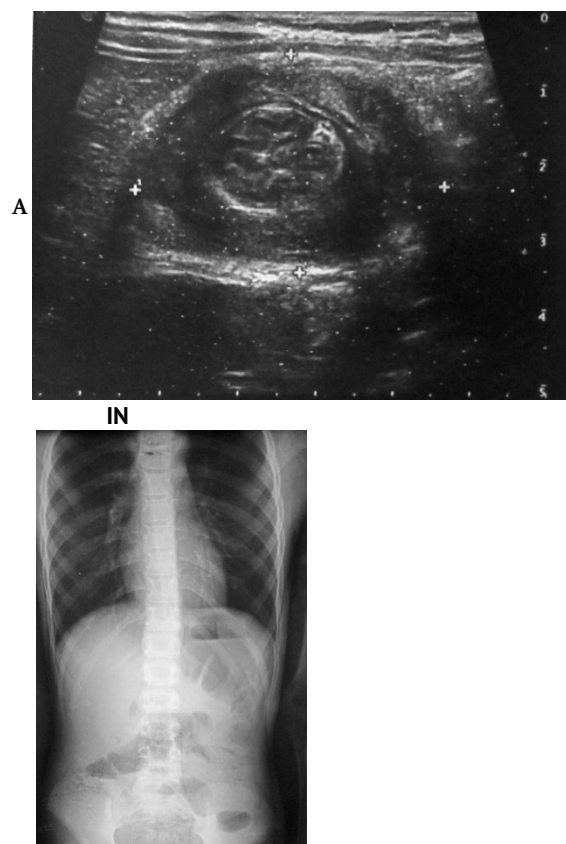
Patient examination data: A – transabdominal ultrasound examination (transverse scan): target-like structure is determined; B – X-ray of abdominal organs in a frontal view, upright position
